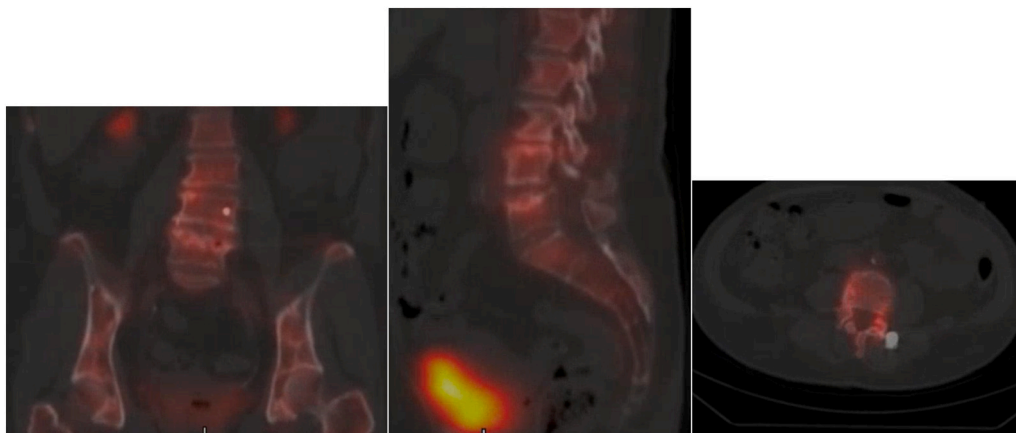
a–c: a) Coronal (left), b) sagittal (middle), and c) axial (right) L4 SPECT CT of the lower thoracic, lumbar, and sacral spine demonstrating elevated uptake along the right aspect of L3–L4, and the superior endplate of L5 with small focal uptake along the left aspect of inferior endplate of L4.
